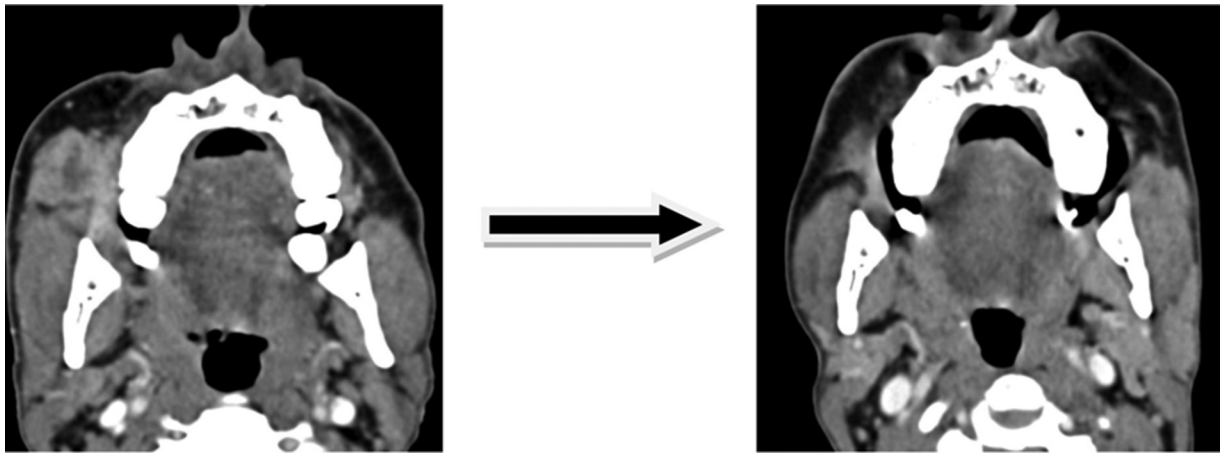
Axial multidetector computed tomography images showing downstaging of T4b disease post induction chemotherapy.
